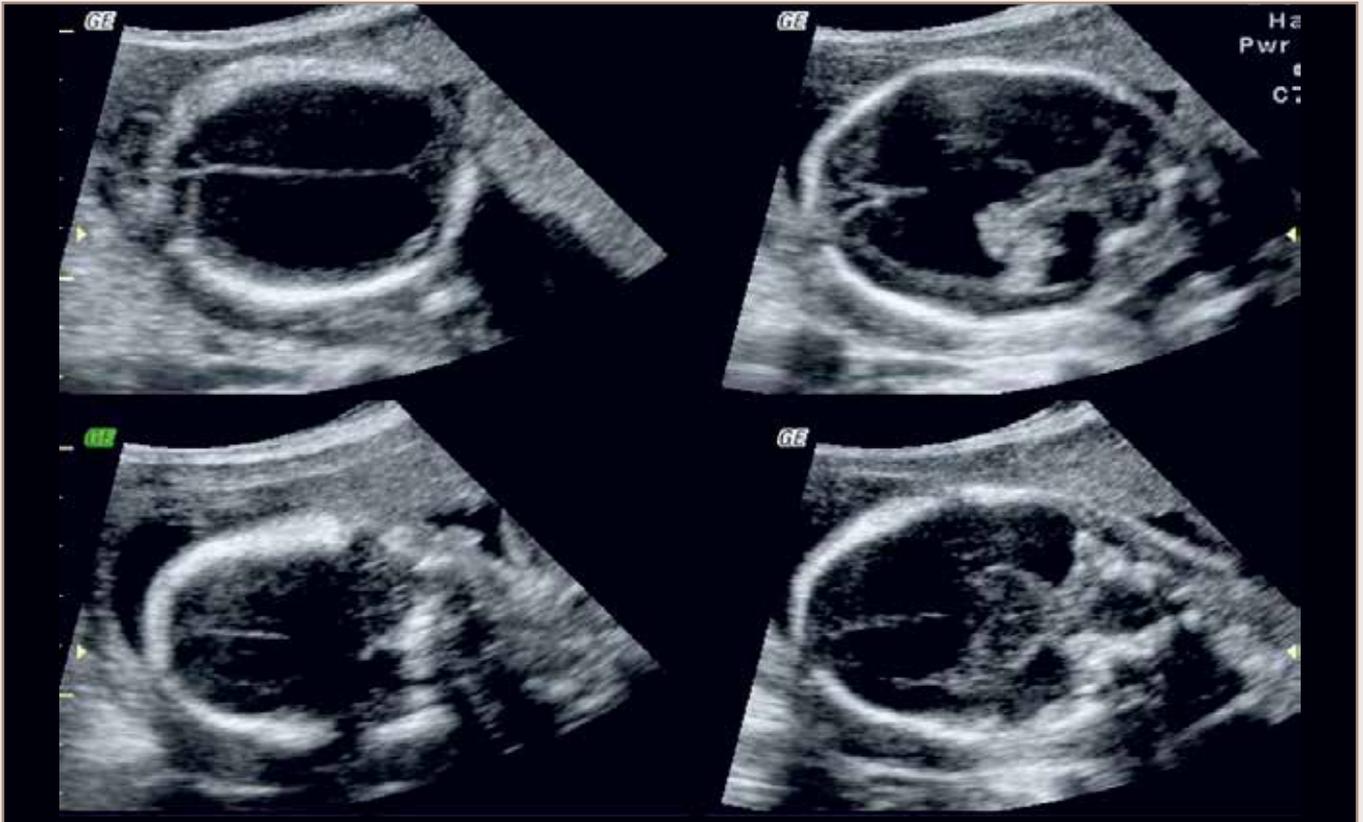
Antenatal Ultrasound Shows Dilated Ventricles, dorsal Cyst,fused Thalami Abortus CT in Axial Coronal and Sagittal Recons Show Semilobar Holoprosencephaly
